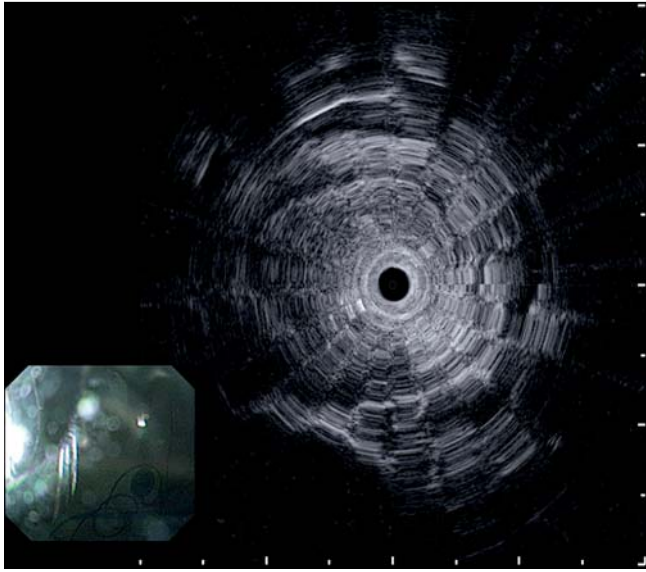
Endoscopic ultrasound revealed an obvious thickening of the mucosal layer of the lesion.
